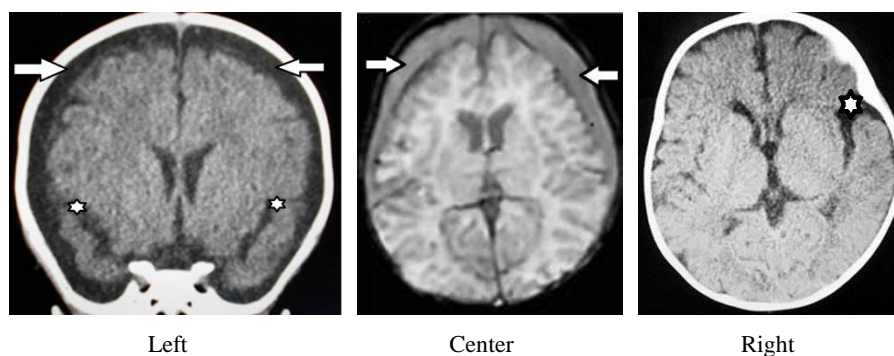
Case 2 (No. 5), female aged 4 months. Left: Coronal view on CT on admission demonstrating large, bilateral, extra-cerebral fluid collections indistinguishable from CSF (arrows). Note the large, bilateral sylvian fissures (stars). Center: Axial view on MRI (SWI) 12 days after onset demonstrating an area of higher signal intensity in the extra-cerebral fluid collections than the CSF, indicating ASDHy. No mass effect or parenchymal abnormality was observed on the other sequences (not shown). Right: CT at post-onset month 5 demonstrating bilateral resolution of ASDHy and residual LSF on the left side (star).
